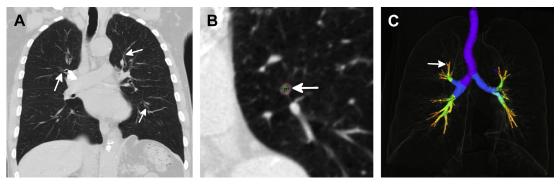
Bronchial wall thickening due to cigarette smoking in an 80-year-old man. (*A*) Coronal image from a chest CT shows diffuse thickening of the bronchial walls (*arrows*). In most instances this is subjectively graded. (*B*) Coronal oblique image though a subsegmental bronchus in the anterior segment of the left upper lobe (*arrow*) demonstrates the ability of specialized computer software to analyze the bronchial lumen and wall thickness. (*C*) With these data, the software can generate a color-coded VRT map depicting various measurements including wall thickness. The airways coded yellow, orange, and red are more severely thickened (*arrow*).
